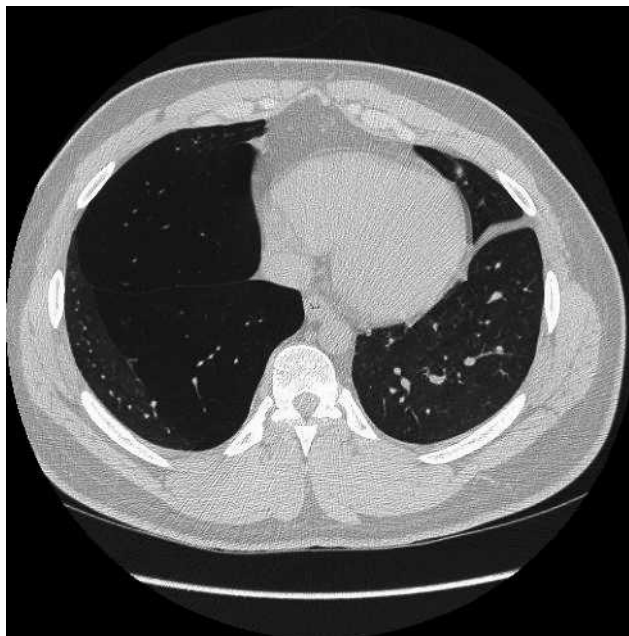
Axial view, computed tomographic scan of the chest.
